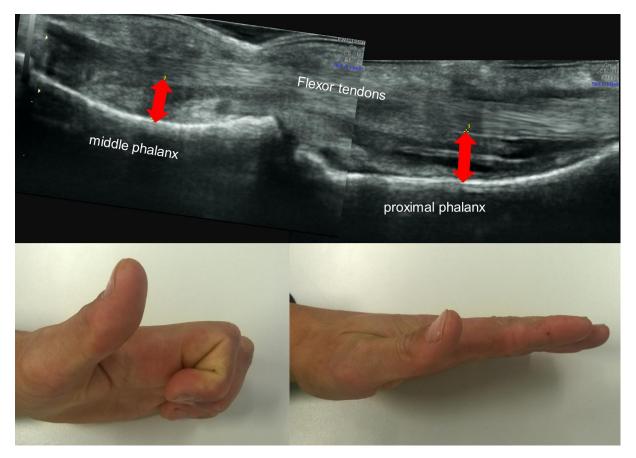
Ultrasound depicts A2 – A4 pulley disruption of the middle finger with spontaneous bowstringing at the proximal and middle phalanx (red arrows). Range of motion after 6 months. The climber went back to level UIAA 10 and worked as a carpenter.
